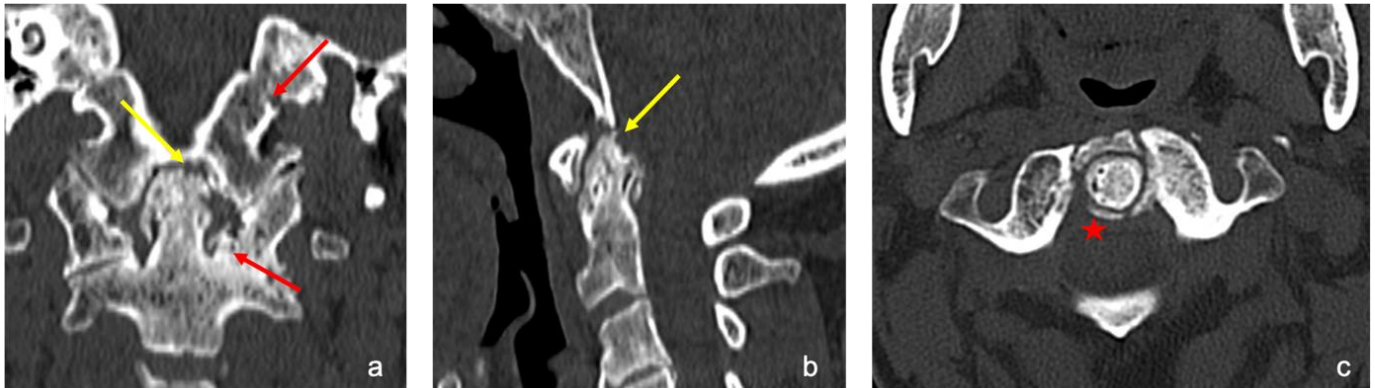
CT scan revealed C1-C2 joint space narrowing with geodes (cyst-like lesions) in the C0-C1 and C1-C2 joints on (a) the coronal view (red arrows), erosion of the odontoid process on (a) coronal and (b) sagittal views (yellow arrow), and calcification of the transverse ligament on (c) the transverse view (red star).
